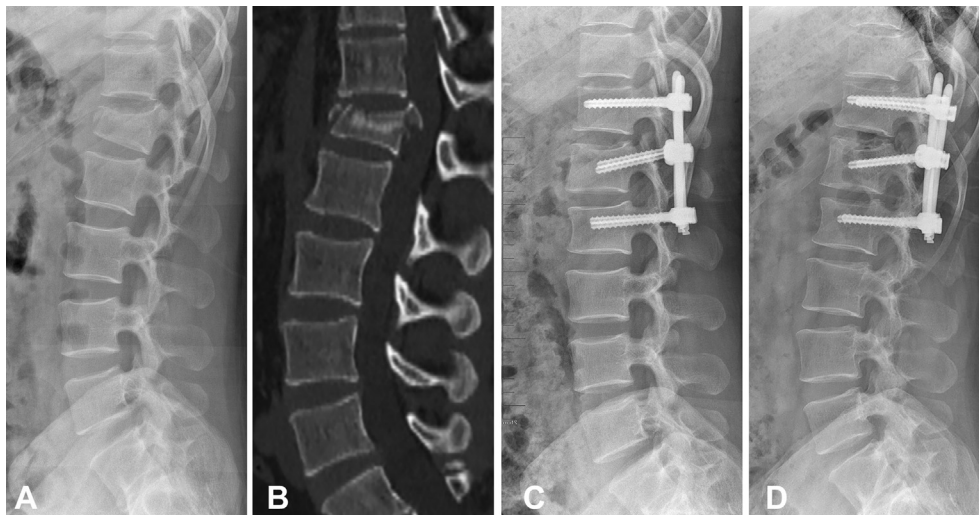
A 30-year-old man with a L1 burst fracture (AO classification: A3, TLICS: 5). (A and B) The lateral radiograph and sagittal computed tomography images obtained before surgery. (C) The patient was treated by MIS. (D) Plain radiograph obtained at the 1-year follow-up. TLICS, Thoracolumbar injury classification and severity scores; MIS, minimally invasive surgery.
